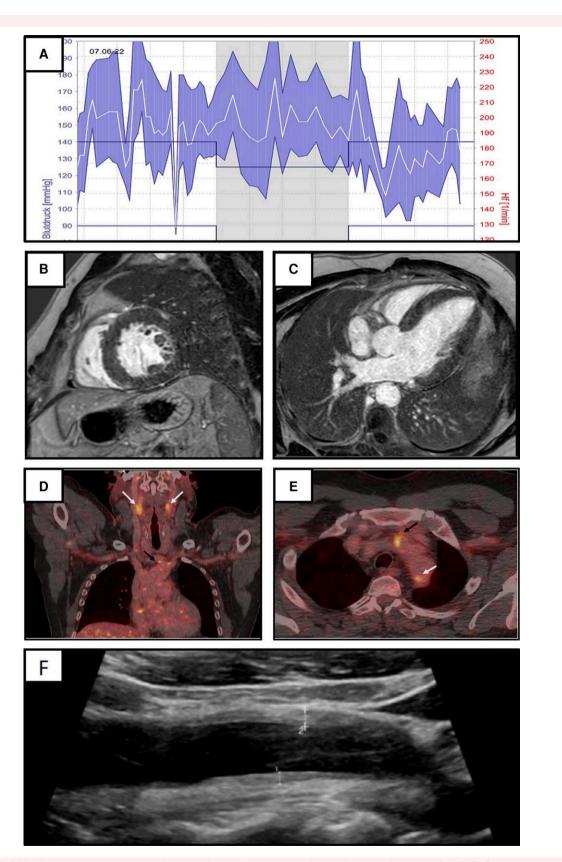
(*A*) 24 h blood pressure monitoring showing substantially increased values and reverse dipping profile. (*B*,*C*) Contrast-enhanced cardiac magnetic resonance imaging showing left ventricular hypertrophy without signs of late gadolinium enhancement or left ventricular outflow tract obstruction. (*D*) ¹⁸F-fluorodeoxyglucose positron emission computed tomography scan showing increased uptake at the origin of the brachiocephalic trunk (black arrow) and the carotid arteries (white arrows). (*E*) Increased tracer uptake at the origin of the brachiocephalic trunk (black arrow) and left subclavian artery (white arrow). (*F*) Vascular sonography of the carotid arteries showing typical homogeneous and hyperechoic wall thickening of the left carotid (2.6 mm) ('macaroni sign').
